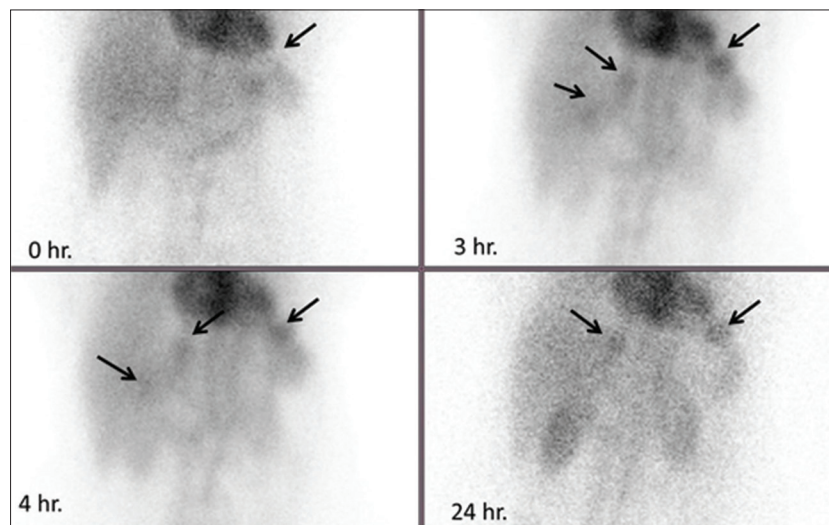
Static images of Tc-99m labelled RBC scintigraphy (in-vivo technique) at 1hr, 3hr, 4hr and 24 hr time points showed initial photopenia (black arrows) with progressive accumulation of radiotracer in left subdiaphragmatic lesion and liver haemangiomas
